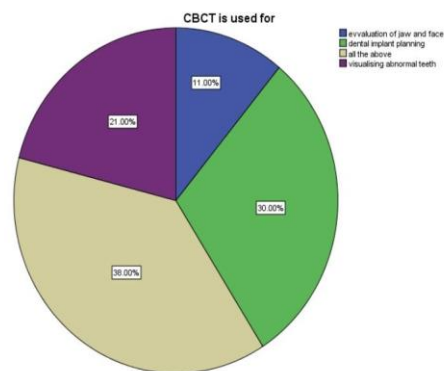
Pie chart shows the knowledge about the uses of CBCT. 11% said that it is used for evaluation of jaw and face , 30% said that it is used for dental implant planning , 21 % said that it is used for visualising the abnormal teeth, and 38% said that it is used for all the above. In that blue indicate the evaluation of jaw and face , green indicate the dental implant planning , purple indicate the visualizing abnormal teeth and grey indicate all the above.
